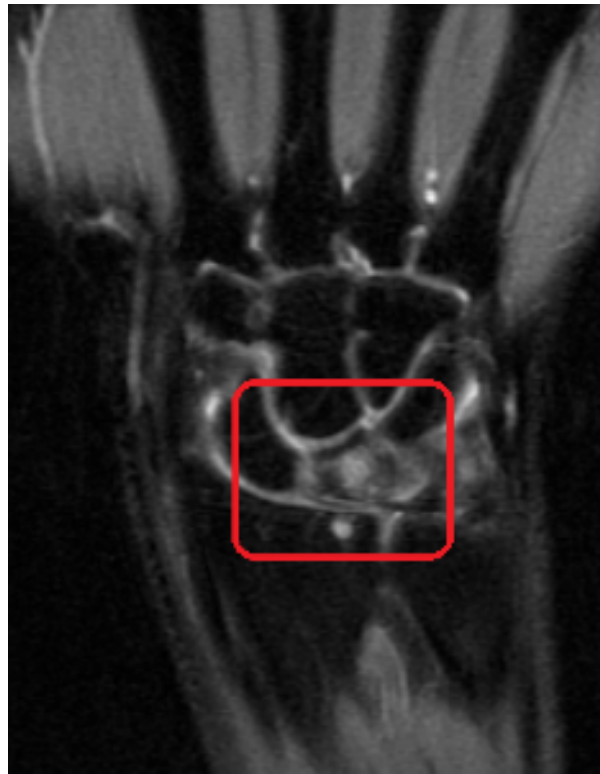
MRI of wrist with Kienbock's (from Radiopaedia.org
